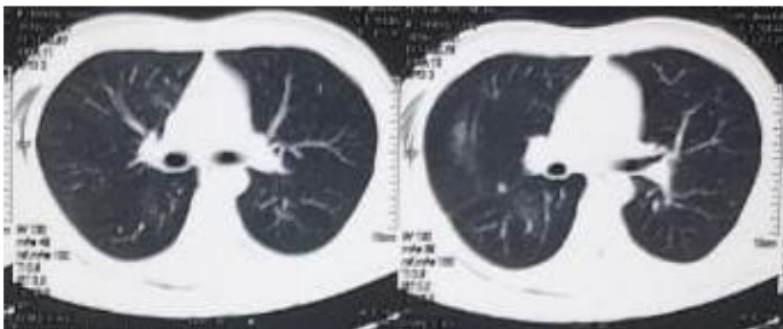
Thoracic CT Scan after chest tube performed
